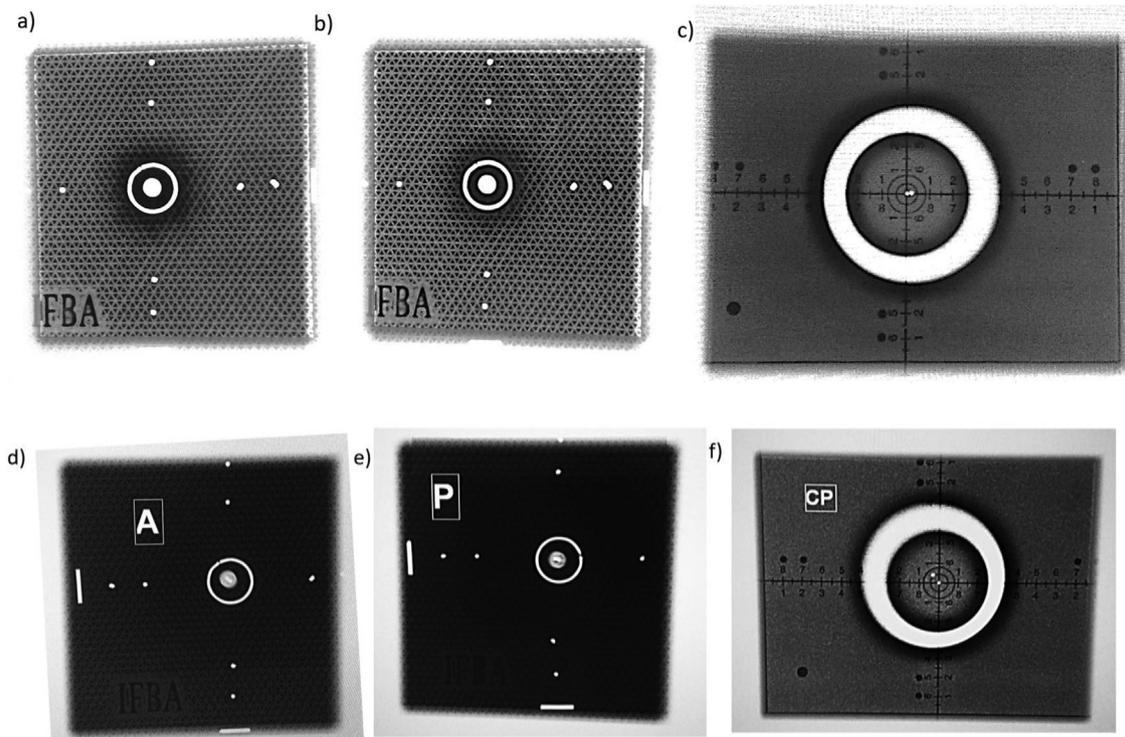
Images from two pieces of X-ray equipment: a) and d) ABS; b) and e) PLA; c) and f) standard tool.
